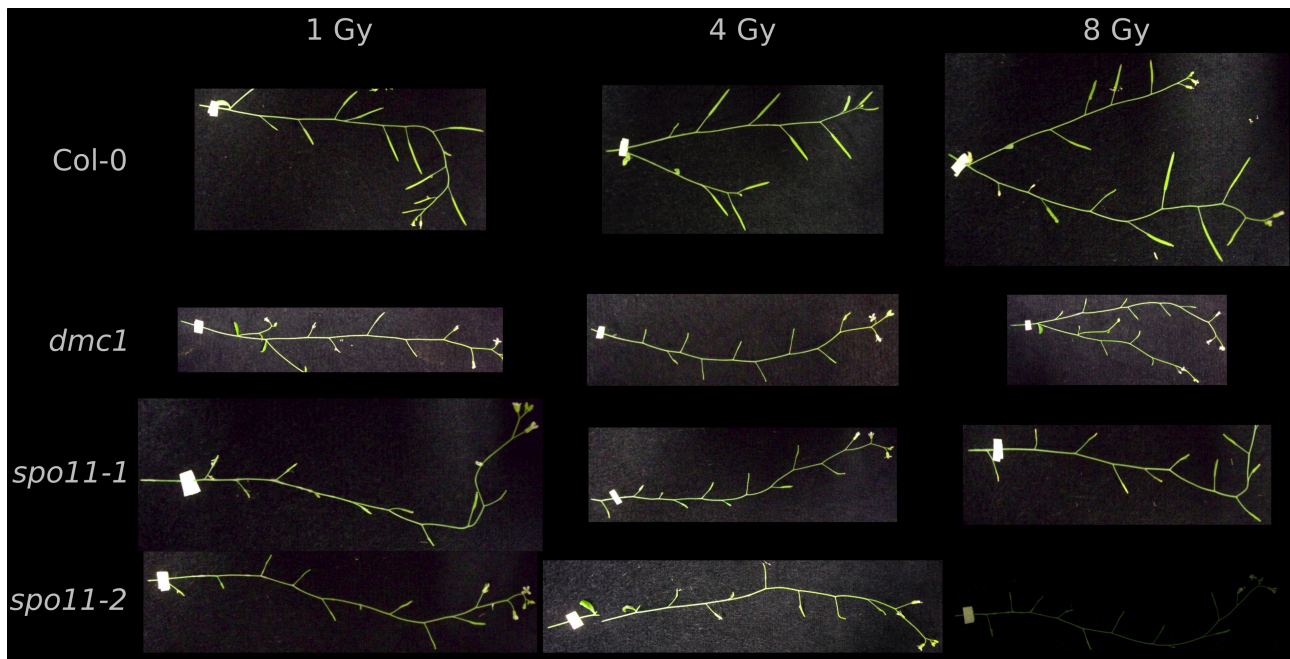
Effects of X-ray radiation on *spo11* mutants.
